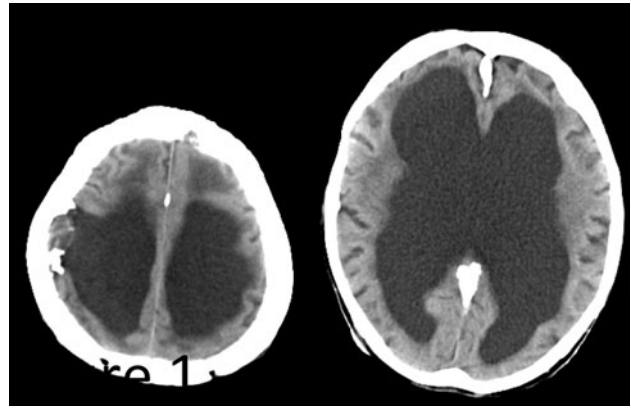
Axial CT image without contrast showing a parietal skull breach due to previous meningioma removal, with parietal calcifications, and extensive calcifications of the tentorium, one of the major criteria for diagnosis of Gorlin's syndrome
